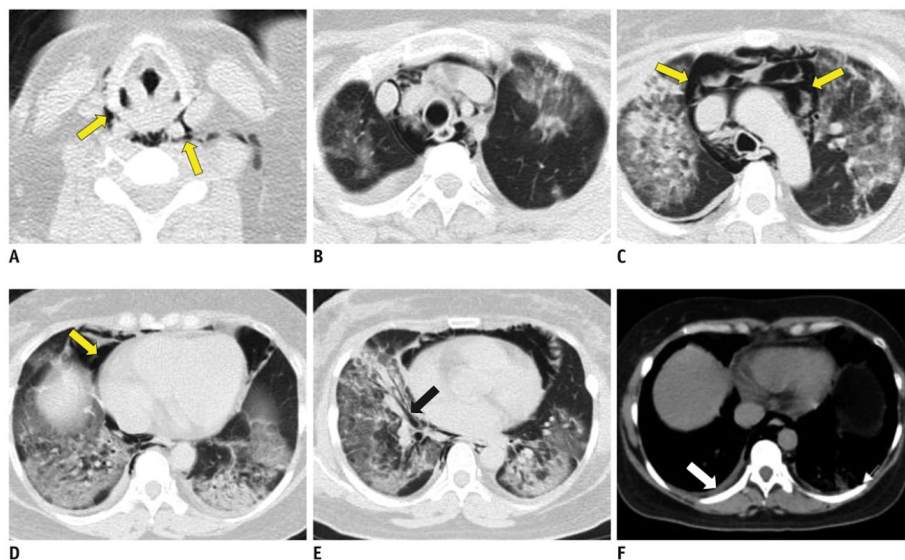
Chest CT of 36-year-old woman with COVID-19 pneumonia obtained 12 days after onset of symptoms.
